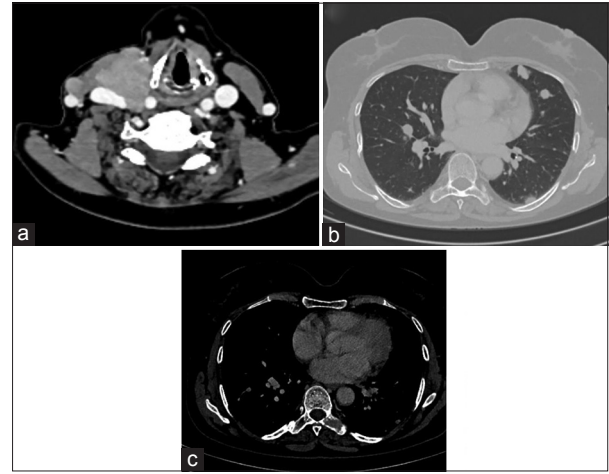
Contrast-enhanced computed tomography scan showing right cervical lymph nodes (a), bilateral pulmonary nodules (b), and lytic destruction of left transverse process of D8 vertebra (c)
